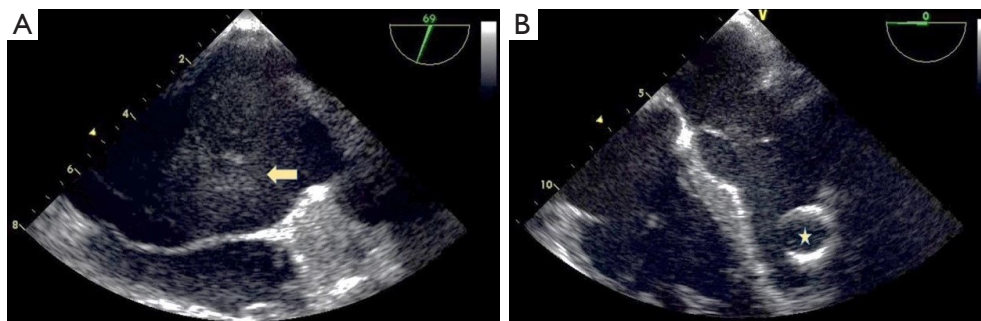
Echocardiography of the heart. (A) Left atrial enlargement, and presence of the intraluminal thrombus (arrow). (B) Asterisk with echographic signal, denoting the presence of VAD in the left ventricle. VAD, ventricular assist device.
